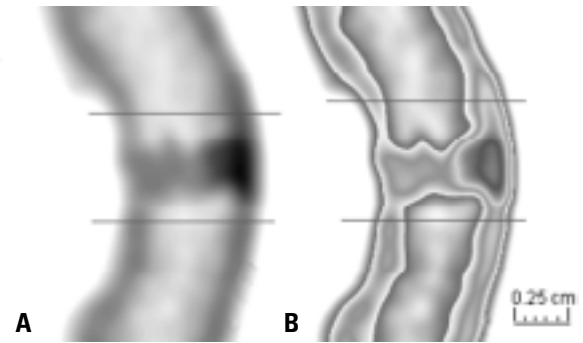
Axial original CT scan of non-obiterated coronal suture (A) and its counterpart (B) after tonal correction. Horizontal lines demarcate the sutural area.
